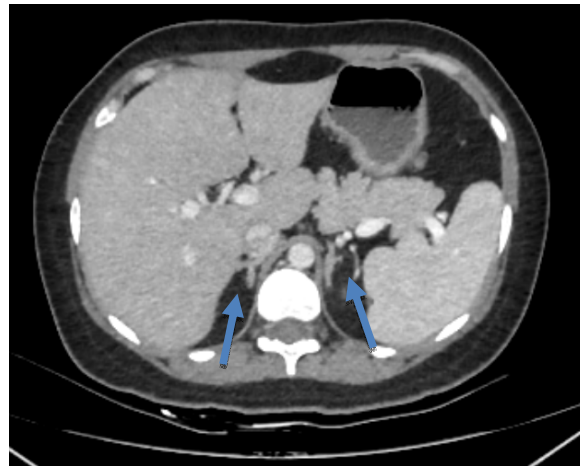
CT of adrenal gland
